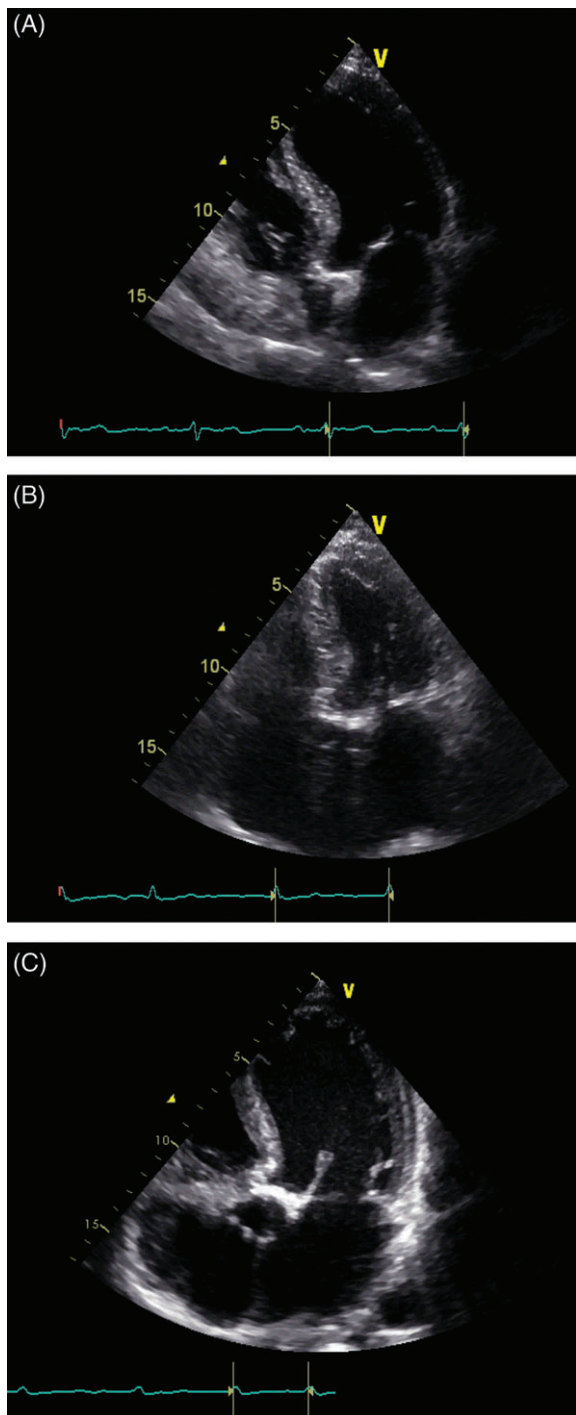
Echocardiographic 5-chamber view. (A) Normal flow/HG AS (normal LVEF, mean gradient >40 mm Hg, AVA <1.0 cm²). (B) Paradoxical LF/LGAS (LVEF >50 mm Hg, mean gradient <40 mm Hg, AVA <1.0 cm², concentric hypertrophy with SVI <35 mL/m²). (C) Classic LF/LGAS (LVEF <50 mm Hg, mean gradient <40 mm Hg, AVA <1.0 cm², LV dilation). Abbreviations: AS, aortic stenosis; AVA, aortic valve area; HG, high-gradient; LF/LGAS, low-flow/low-gradient aortic stenosis; LV, left ventricular; LVEF, left ventricular ejection fraction; SVI, stroke volume index.
